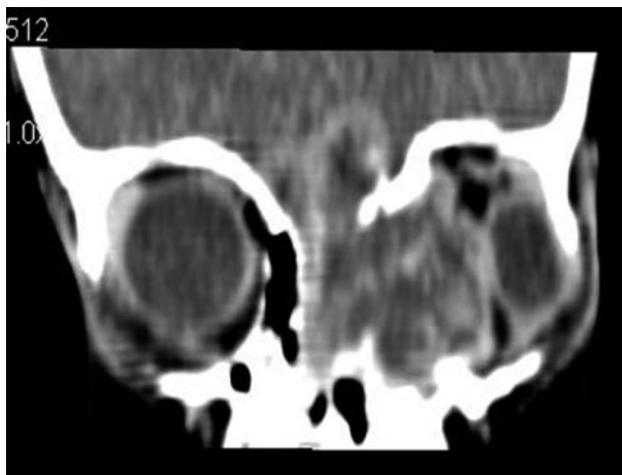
Postcontrast reformatted coronal CT shows septal and peripheral enhancement of the mass with extension into left maxillary sinus and anterior cranial fossa.
